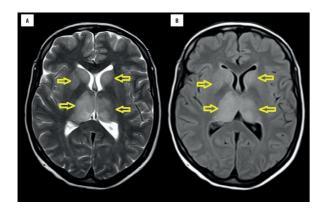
Axial T2-weighted MRI image (A) and FLAIR image (B) displaying bilateral hyperintense lesions within the basal ganglia and the thalamus (arrows).
